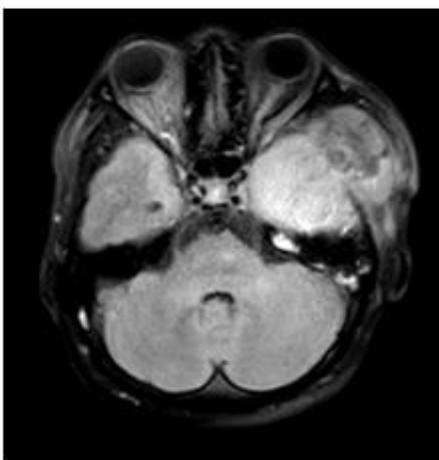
MRI Head Results Without Contrast Of Second Patient
